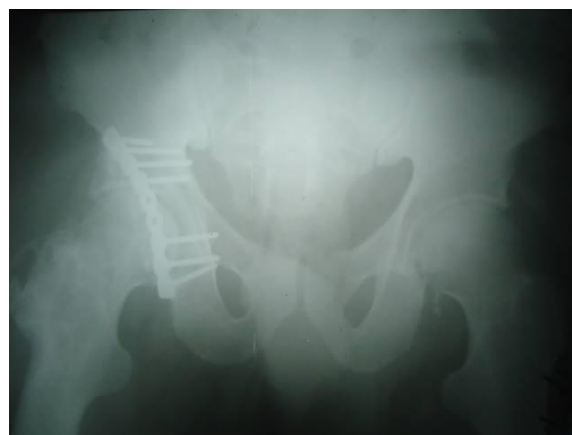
Post-operative pelvic x-ray
